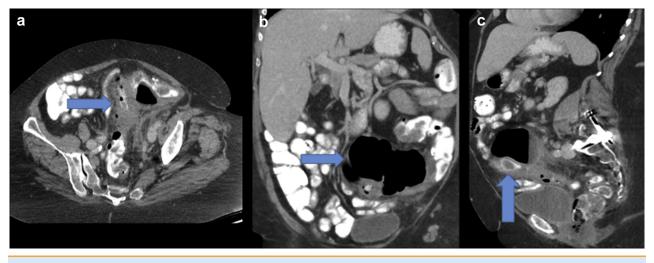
(a-c) Axial, coronal, and sagittal contrast-enhanced abdominal CT images from a 43-year-old woman who presented to the emergency department with a 5-day history of lower abdominal pain. The images show a perforated appendicitis with a >1 cm appendicolith in the right lower pelvis. The abscess involves the right adnexa and fallopian tube. The blue arrows show an abscess secondary to a perforated appendicitis with a >1 cm appendicolith in the right lower pelvis.
